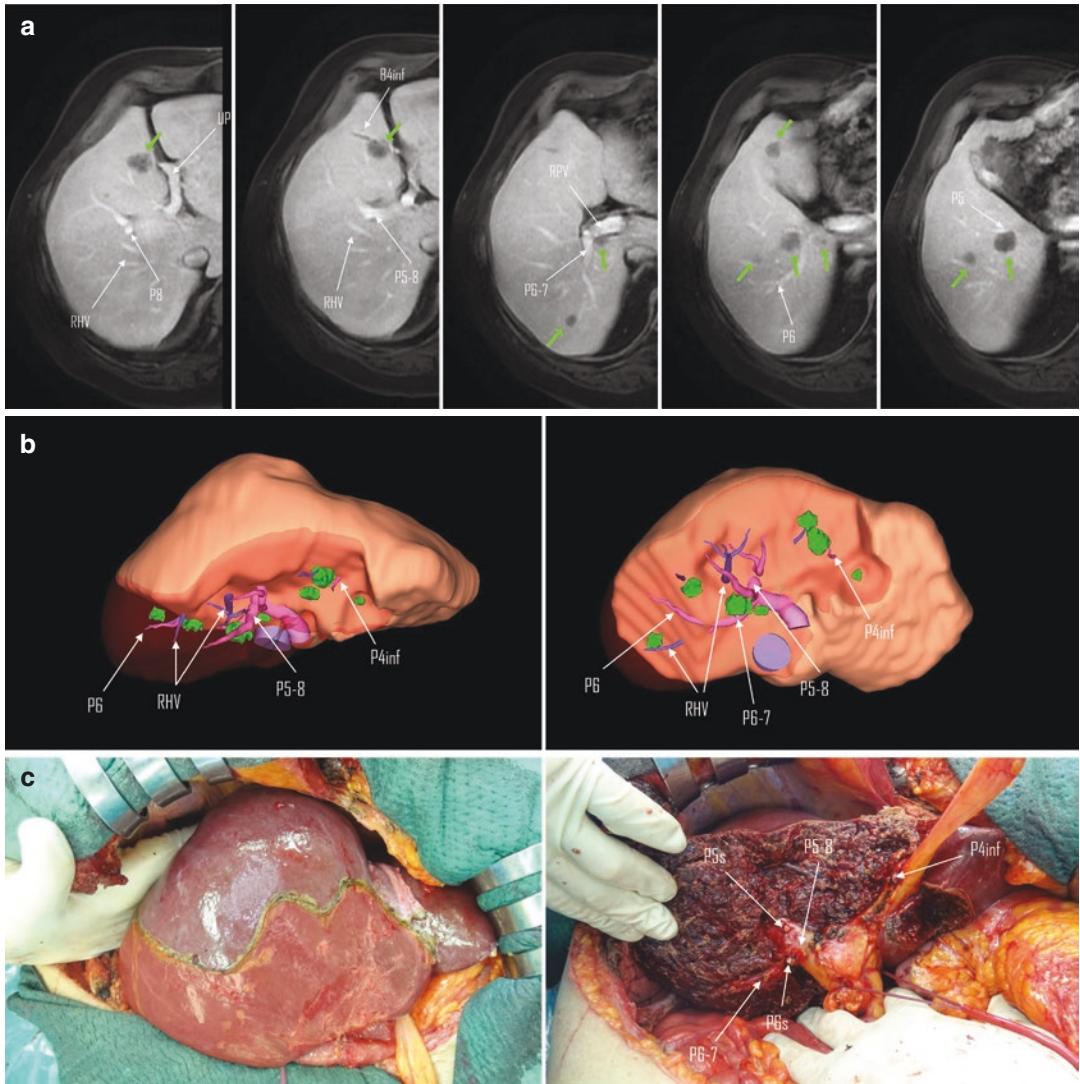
Lower transversal hepatectomy for multiple colorectal liver metastases. (a) Preoperative magnetic resonance imaging shows multiple lesions (green arrows) with one in contact with portal branch to right posterior section and one involving the Glissonean pedicle for segment 4 inferior with subsequent segmental bile duct dilation. (b) Preoperative three-dimensional virtual cast showing the bilateral distribution of the lesions in an estimated future liver remnant of 70% and the surgical plan.
